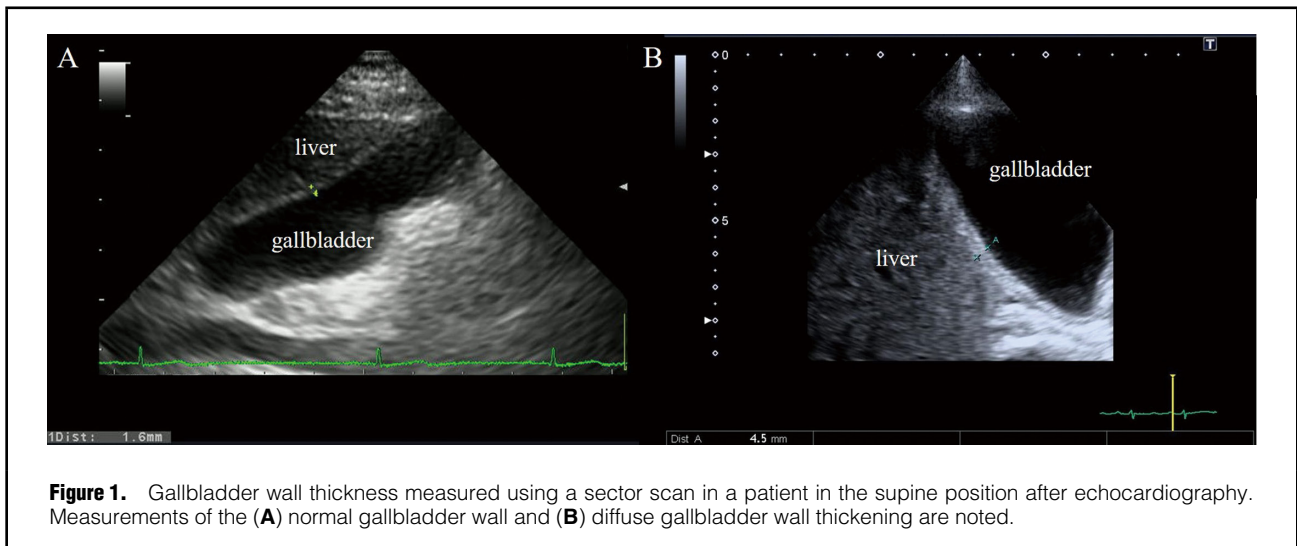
Gallbladder wall thickness measured using a sector scan in a patient in the supine position after echocardiography. Measurements of the (A) normal gallbladder wall and (B) diffuse gallbladder wall thickening are noted.
